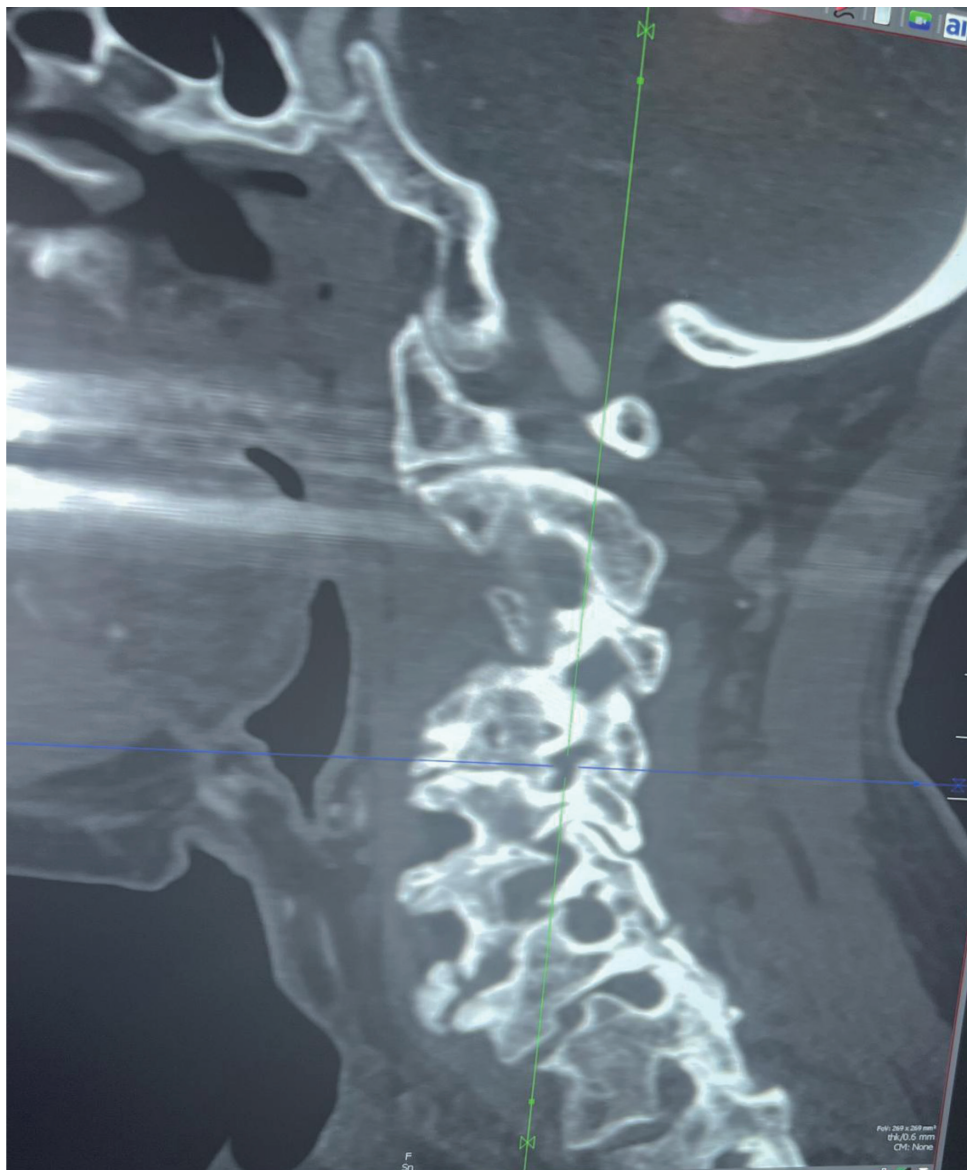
CT of the cervical spine: view of the right foramina showing moderate to severe foramen stenosis in C3-C4 and C5-C6 and severe stenosis in C2-C3. CT: computed tomography.
